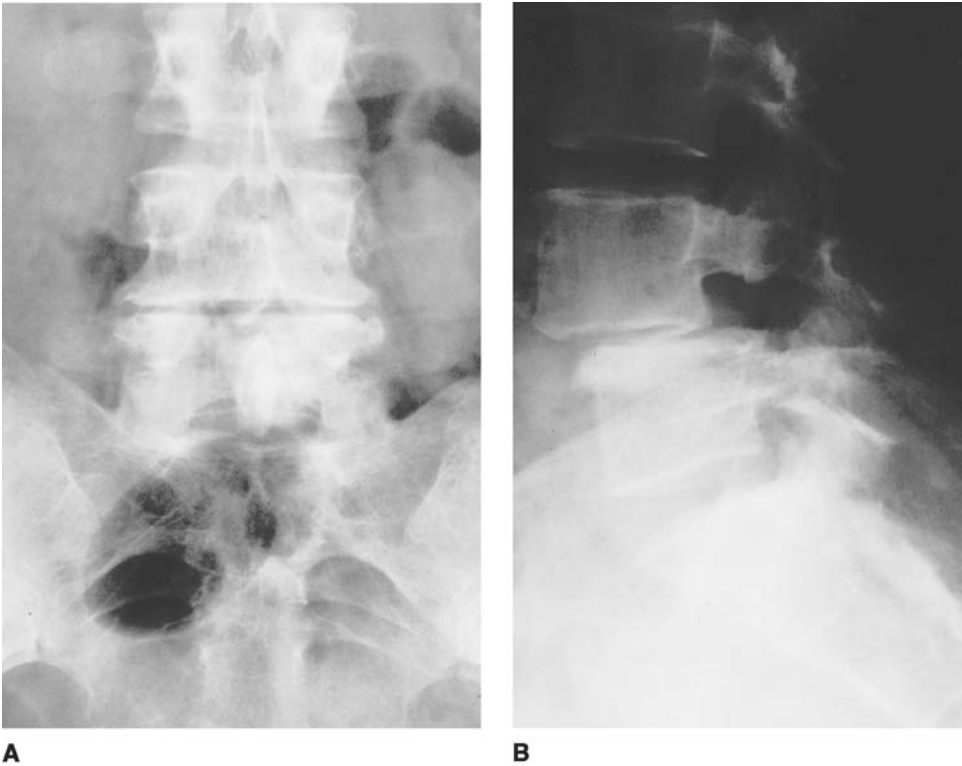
(A,B) Preoperative lumbar spine AP and LL roentgenogram views showing a II degree L4-L5 isthmic spondylolisthesis in a 46-year-old female employee affected by low back pain and bilateral L4, L5, and S1 radiculopathy over the last 3 years. A large Gill's nodule and lateral recess stenosis were observed encroaching the L4-L5 and S1 roots at the L4-L5 and L5-S1 levels, respectively, on MRI (not reported here). (C,D) Preoperative lumbar spine roentgenogram oblique views showing the lytic defect in the L4 pars interarticularis. The patient was scheduled for an instrumented L4-L5 postero-lateral fusion and L4-L5, L5-S1 decompression by lamino-foraminotomy (fenestrectomy). (E,F) Postoperative lumbar spine roentgenogram AP and LL views showing postero-lateral fusion with autogeneic bone grafts (see also Fig. 1) instrumented by transpedicular monoaxial screw fixation augmented by a transverse connector (Isola® System). The patient was well at 3-year follow-up.
